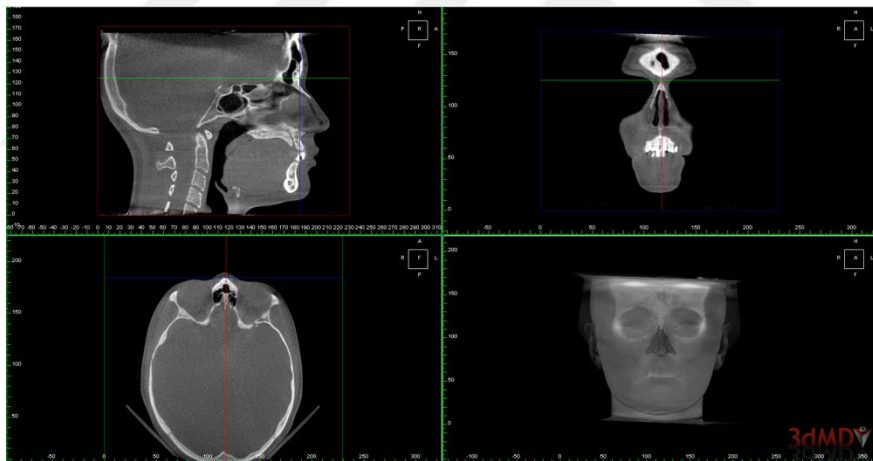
Determination of Nasion point on CBCT
